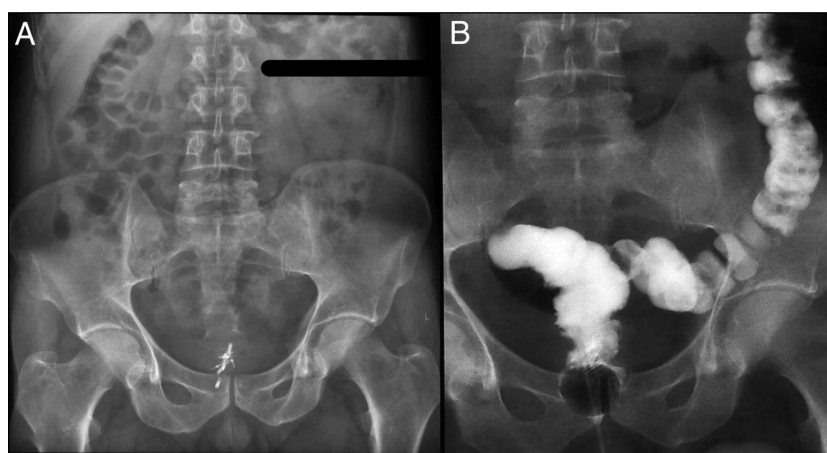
(A) Postprocedure X-ray revealed the intact clips approximated together. (B) Contrast study on day 7 postprocedure revealed no signs of leak with clips intact.
